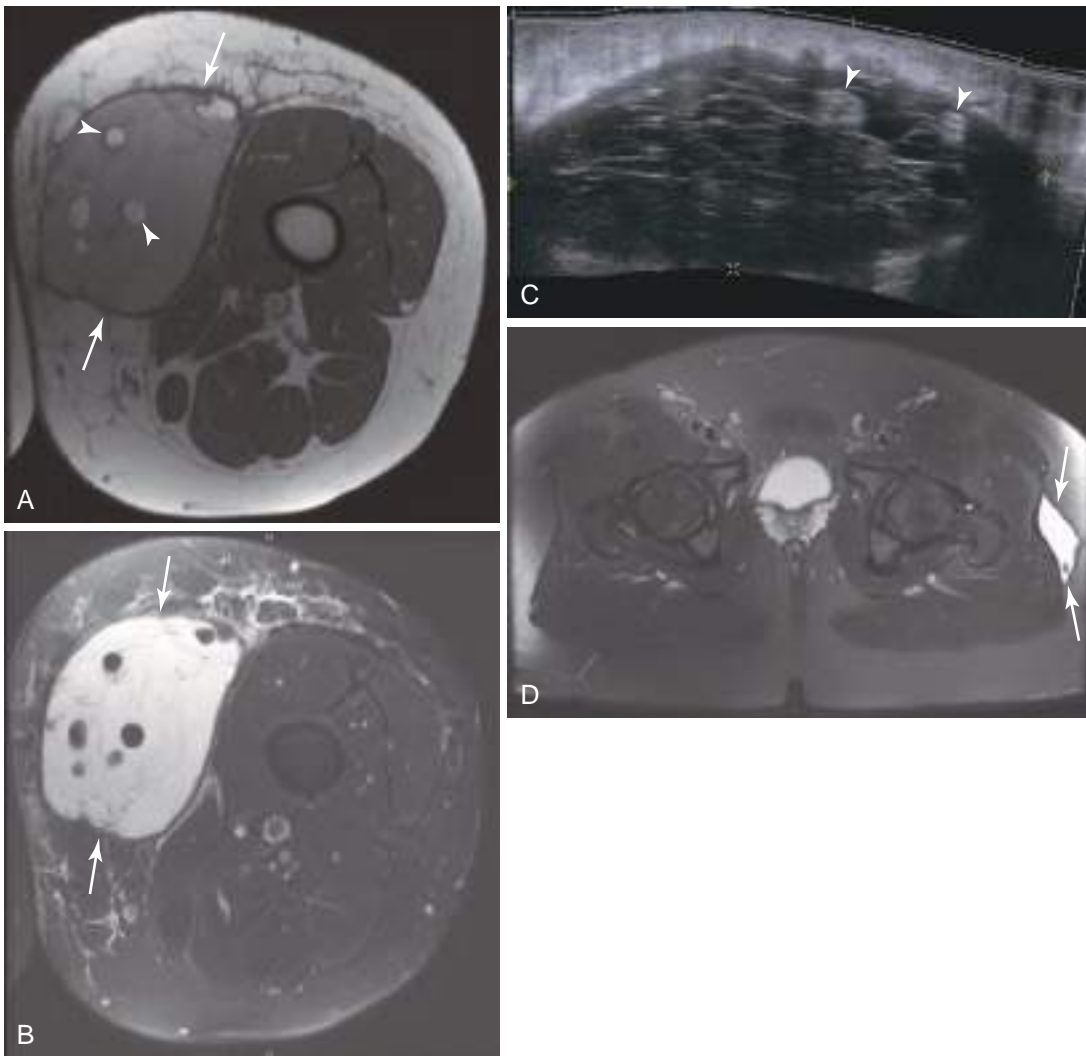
Morel-Lavalée lesion in the thigh. (A) Axial T1-weighted and (B) fat-suppressed T2-weighted MR images and (C) longitudinal US. This lesion has many of the features that are variably present in Morel-Lavalée lesions, including a surrounding low-signal pseudocapsule (*arrows*), innumerable internal thin septations, fat lobules within the lesion (*arrowheads*), and mass effect on adjacent musculature. Note the characteristic location between subcutaneous fat and superficial muscle fascia. The medial location of this lesion is somewhat atypical, as most lesions occur laterally. (D) Smaller lesion in a different patient, lateral to the left hip.
